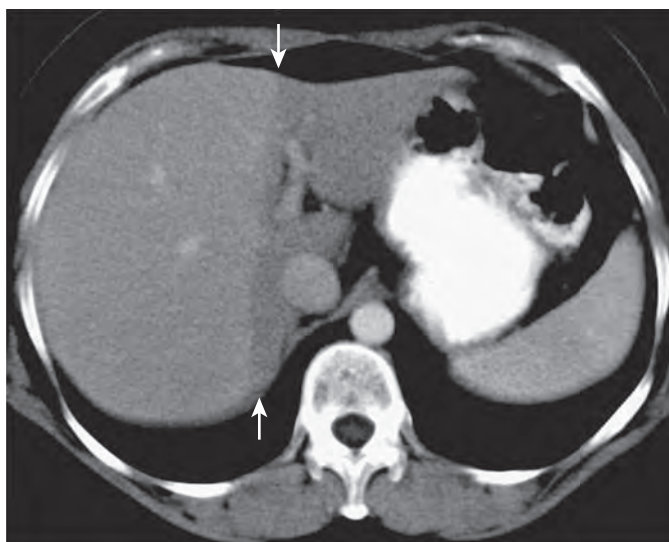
Radiation-induced hepatic injury. Contrast-enhanced CT scan shows a sharply defined region (arrows) of hepatic hypoattenuation near the dome of the liver. This patient had received external beam radiation therapy for lung carcinoma.
